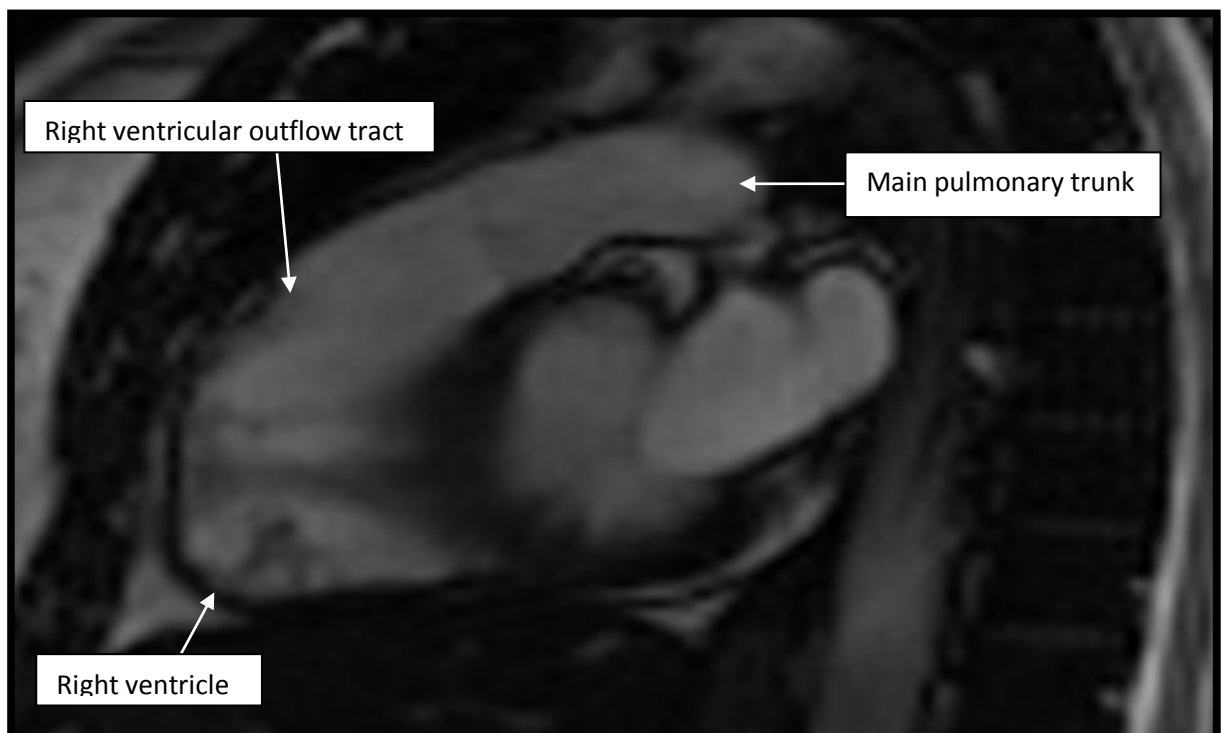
MRI CINE right ventricular outflow tract at diastole
